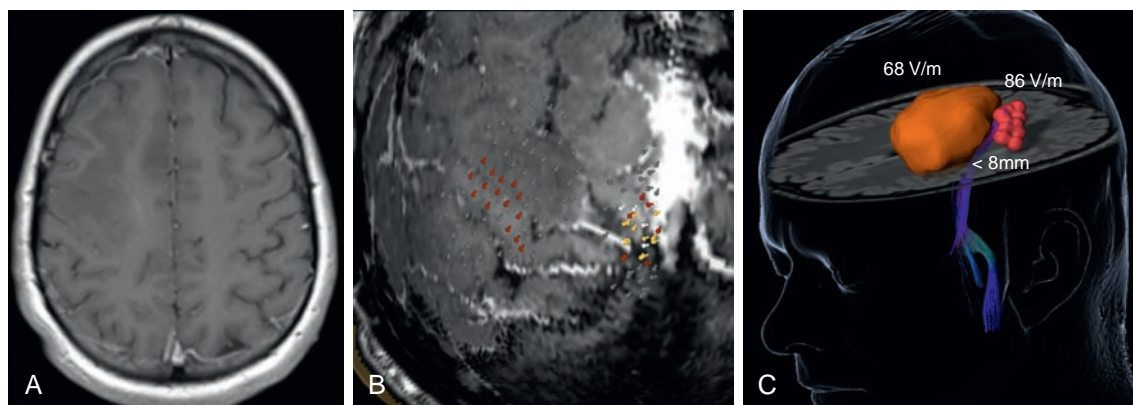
Transcranial magnetic stimulation (TMS) risk stratification for lesions presumably affecting the motor system. (A) Axial T1 contrast enhanced MRI scan demonstrating a hypointense lesion of the posterior frontal lobe in a 37-year-old man with a discrete coordination impairment of his left hand. (B) TMS mapping result. Colored pins = TMS-induced motor evoked potentials outlining the primary motor cortex for hand and lower limb muscles (red = motor evoked potential [MEP] 50–500 μ V; yellow = MEP 500–1000 μ V; white = MEP > 1 MV; gray = no primary motor function). (C) Three-tier risk stratification. (1) Targeted resection volume (orange) does not involve the primary motor cortex (red). (2) Minimal distance between targeted resection volume and TMS-derived corticospinal tract <8 mm (increased risk). (3) Resting motor threshold (RMT): left, 86 V/m; right, 68 V/m = pathologic excitability profile (increased risk). The results indicate a high-risk case in terms of probability of a new motor deficit after surgery; statistically the risk for a new motor deficit after 3 months is 47% in this case.
